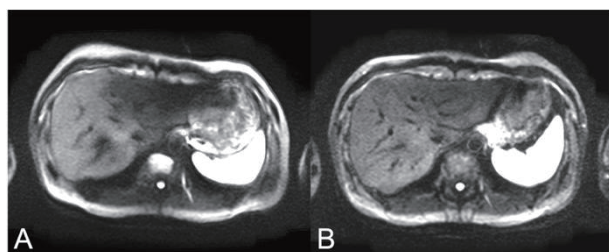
A representable image of conventional DWI (A) and Real-time platform applied DWI (B).
